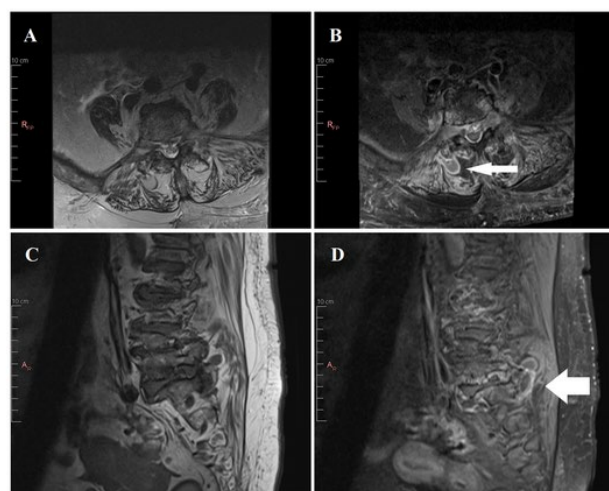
T2-weighted (A) and fat-saturated contrast-enhanced T1-weight (B) magnetic resonance images demonstrating joint effusion at the right L5-S1 facet joint (thin arrow). T1-weighted (C) and fat-saturated contrast-enhanced T1-weight (D) magnetic resonance images demonstrating synovial contrast enhancement at the right L5-S1 facet joint (bold arrow).
